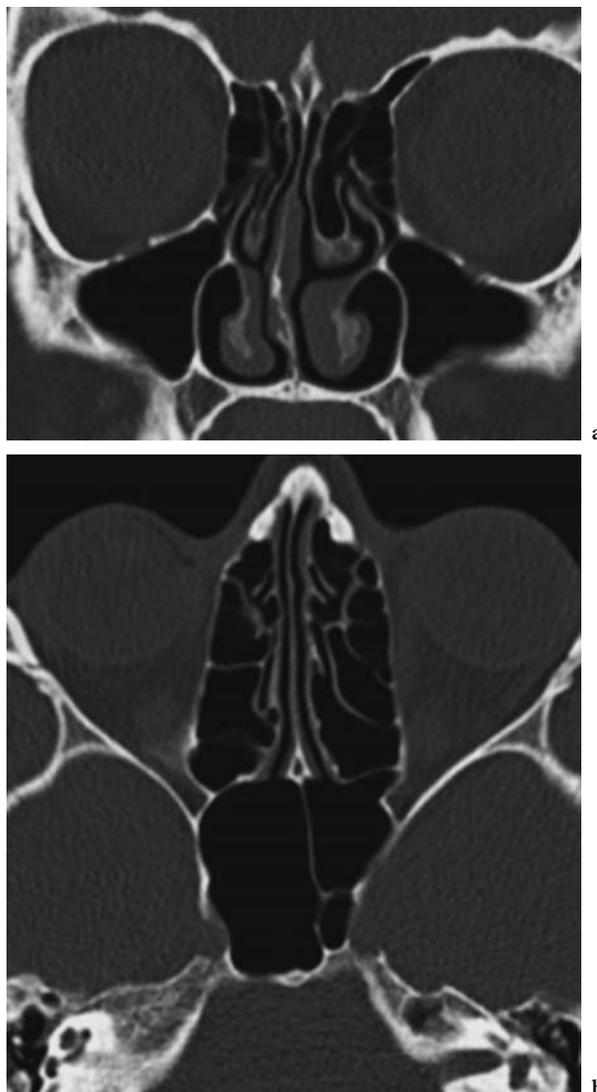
A 24-year-old woman with suspicion of chronic sinusitis. Low-dose 16-MDCT at 120 kV and 25 mAs ($CTDI_{vol}$ of 5.2 mGy) with 2 mm coronal (a) and axial (b) images show clearly the normal anatomy of the osteomeatal units and infundibulum with clear aeration of both maxillary, ethmoidal and sphenoidal sinuses. Calculated effective dose of CT exam is 0.10 mSv
